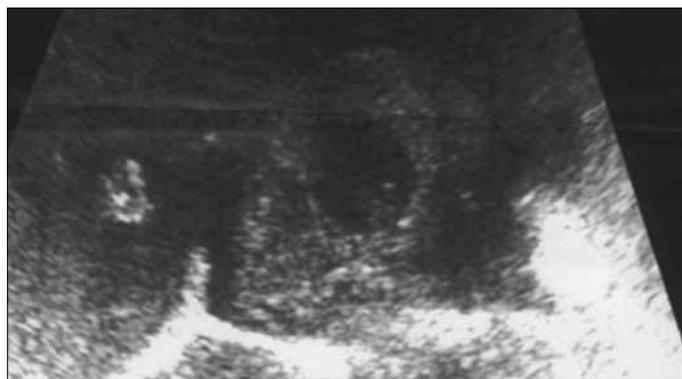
Transabdominal sonography
